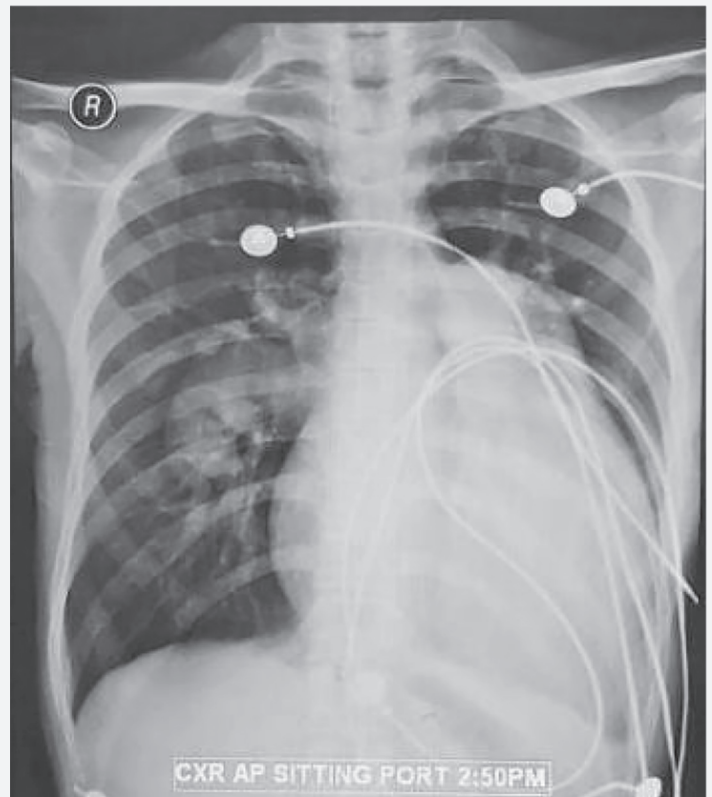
Chest x-ray anteroposterior view: Dilated central pulmonary arteries, cardiomegaly predominantly showing right ventricular enlargement and marked left atrial enlargement.
